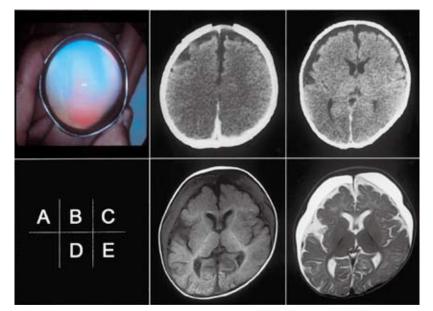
A: A fundal hemorrhage was observed on admission using a magnifier lens. B, C: In the brain CT performed on admission, a region of high absorbance was observed along the cerebral falx, resulting in the diagnosis of subdural bleeding. D, E: In both the T1-weighted image (D) and T2-weighted image (E) of the brain MRI performed on Day 17 of hospitalization, crescentic regions exhibiting high signals were observed beneath the dura mater on both sides.
